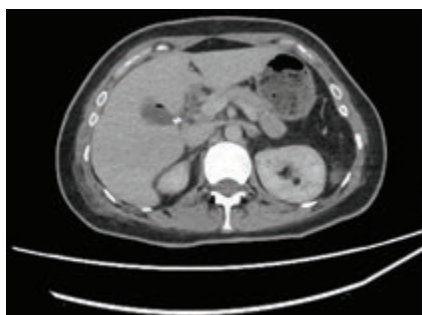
Axial enhancing computed tomography image revealing dense fluid collection in the gall bladder fossa with clips after surgery
